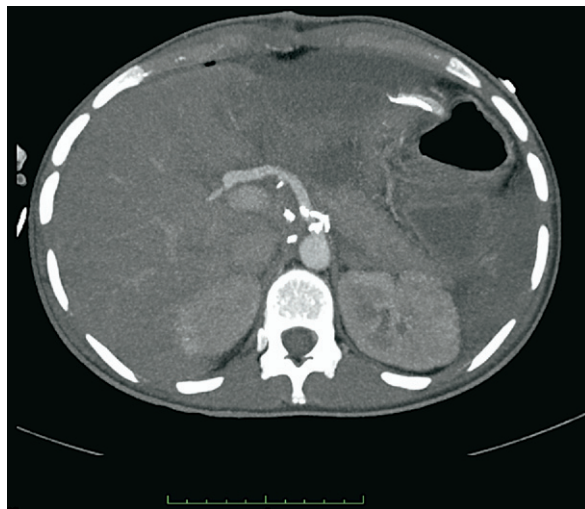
Computed tomography scan after successful revascularization by vein graft to right hepatic artery.
